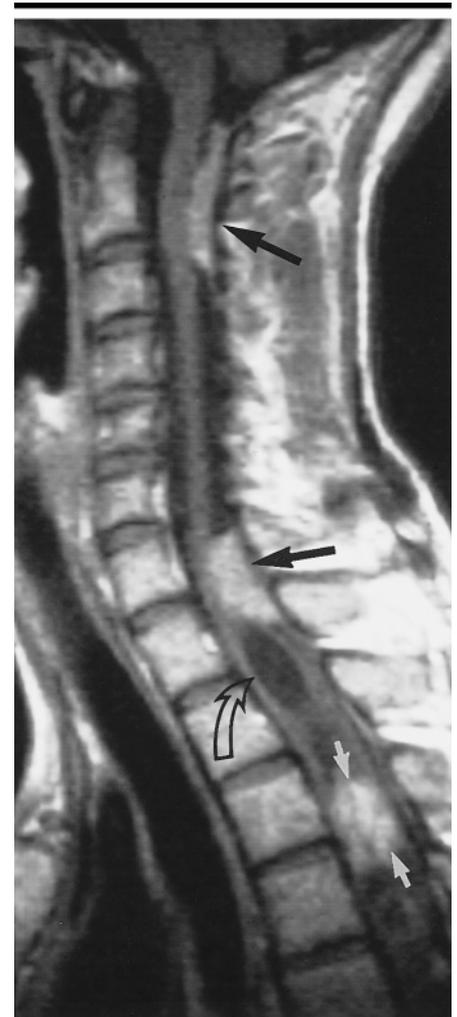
Sagittal contrast-enhanced T1-weighted MR image (550/22) of the cervical spine. Extramedullary enhancing dural-based tumors (meningiomas) are seen at the C2 and C7-T1 levels (black solid arrows). The tumor at the C7-T1 level results in cord compression. In addition, an enhancing intramedullary tumor (white solid arrows) at the T3-T4 level causes focal cord engorgement. An associated syrinx (open arrow) is seen in a small segment of the cord proximal to this tumor.
